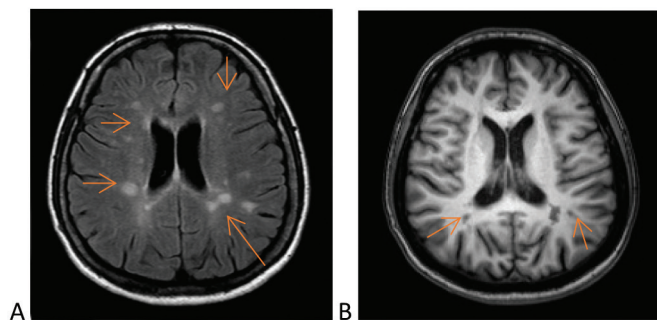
MRI of the brain. A / Image of multiple hypersignal lesions (T2 weighted image) in both cerebral hemispheres. B / Image with hyposignal lesions (T1 weighted image).
